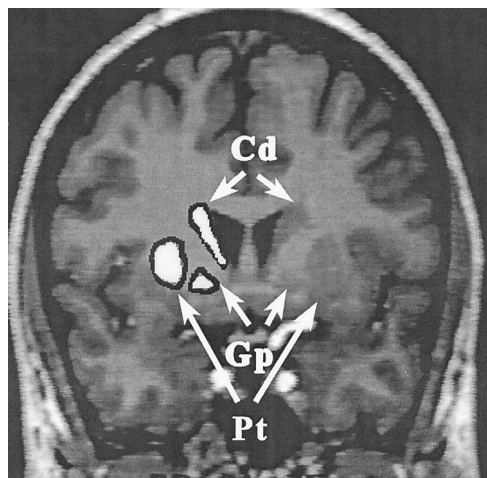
A typical coronal MR image with the head of the caudate nucleus (Cd), the putamen (Pt), and the globus pallidus (Gp) highlighted.
